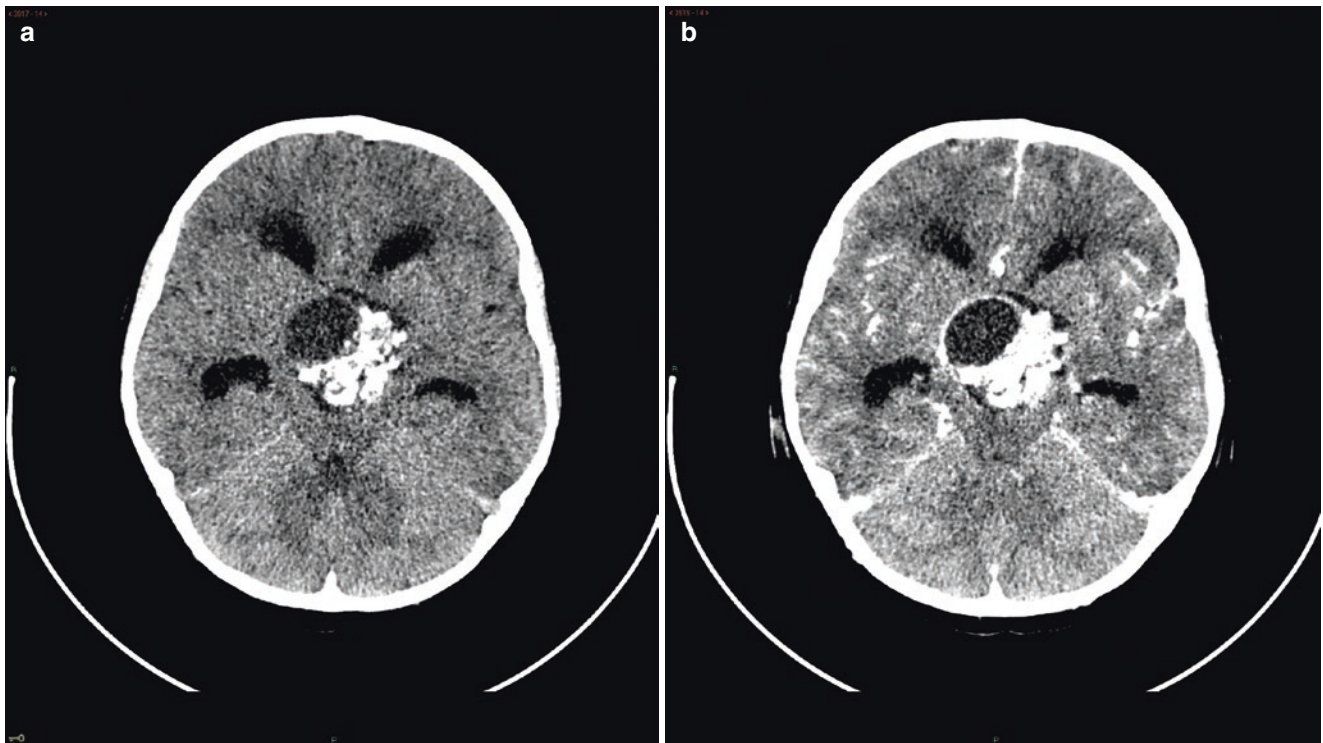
Craniopharyngioma. (a) Axial CT image demonstrates a calcified and cystic lesion in the suprasellar region. There is hydrocephalus affecting the lateral ventricles. (b) Following contrast administration, there is rim enhancement of the cystic component
